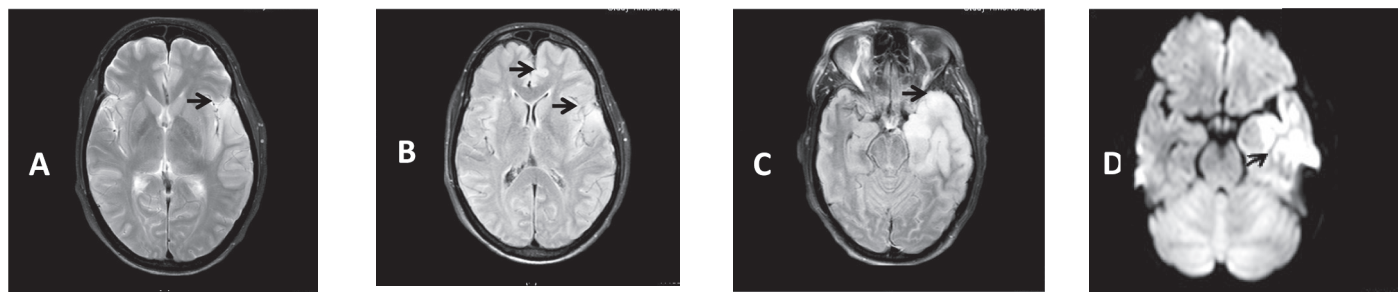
MRI in Herpes simplex encephalitis
